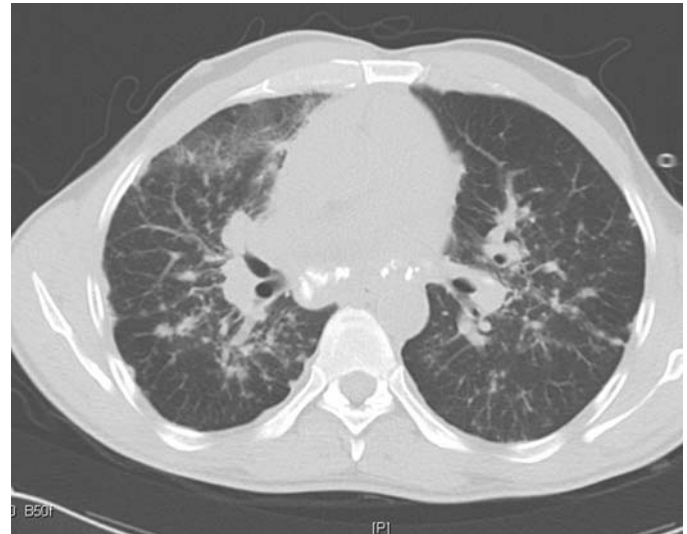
FIGURE e24-21 Sarcoid—CT scan of stage II (calcified lymphadenopathy, parenchymal infiltrates).
